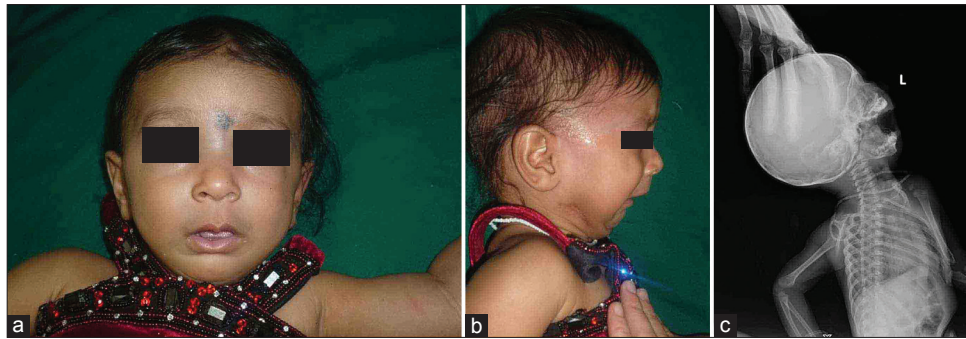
Postoperative images showing the frontal, profile views and the lateral skull radiograph
